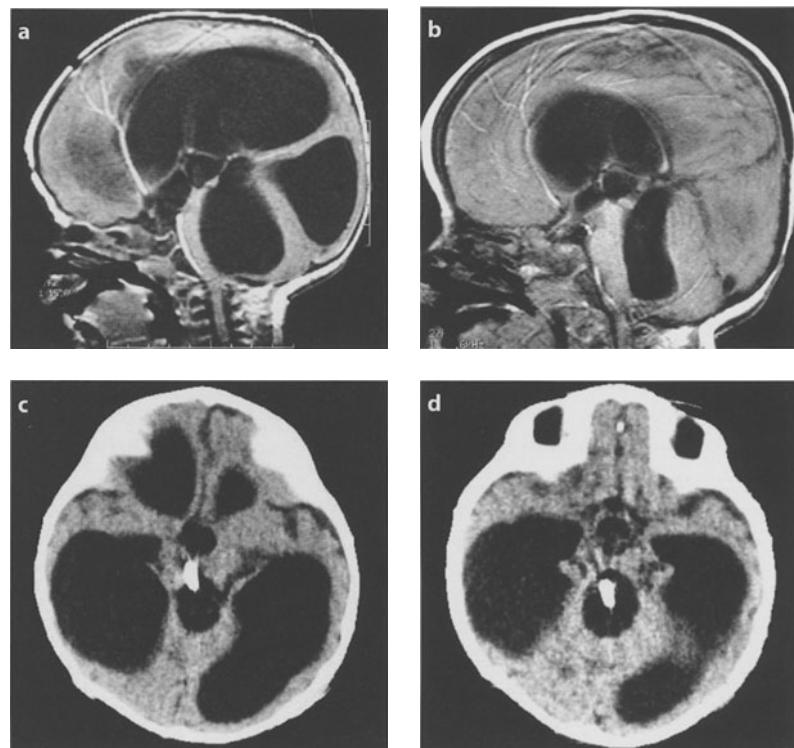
a-d. Three-month-old baby girl, posthemorrhagic tetraventricular hydrocephalus with trapped fourth ventricle. a Preoperative and b Postoperative sagittal T1-weighted MRI. Endoscopic aqueductoplasty has been performed and a ventricular catheter has been inserted through a right coronal burr hole and connected to a peritoneal shunt system. c, d View of the catheter across the aqueduct
